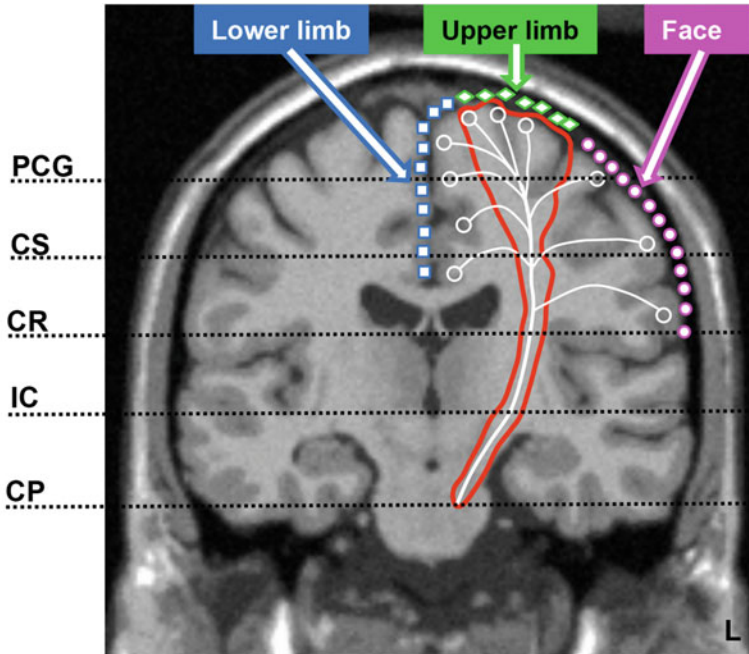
An atlas comprised of the corticospinal tract (CST) and the upper limb/respiratory muscles somatotopy in the left side was overlaid onto a coronal orientation T1-MRI template in Montreal Neurological Institute coordinate space. The somatotopic arrangement within the primary motor cortex and its approximate anatomical regions are shown (the filled circles, diamonds, and squares represent the face, upper limb, and lower limb somatotopies, respectively). The circles and the lines represent the motor nuclei and the axons, respectively; the axons coalesce to form CST, which traverses inferiorly toward the brainstem. The horizontal dashed lines indicate the approximate anatomical levels at which the five segments were made along the length of the CST. PCG, precentral gyrus; CS, centrum semiovale; CR, corona radiata; IC, internal capsule or posterior limb of IC; CP, cerebral peduncle; L, left side of the subject
